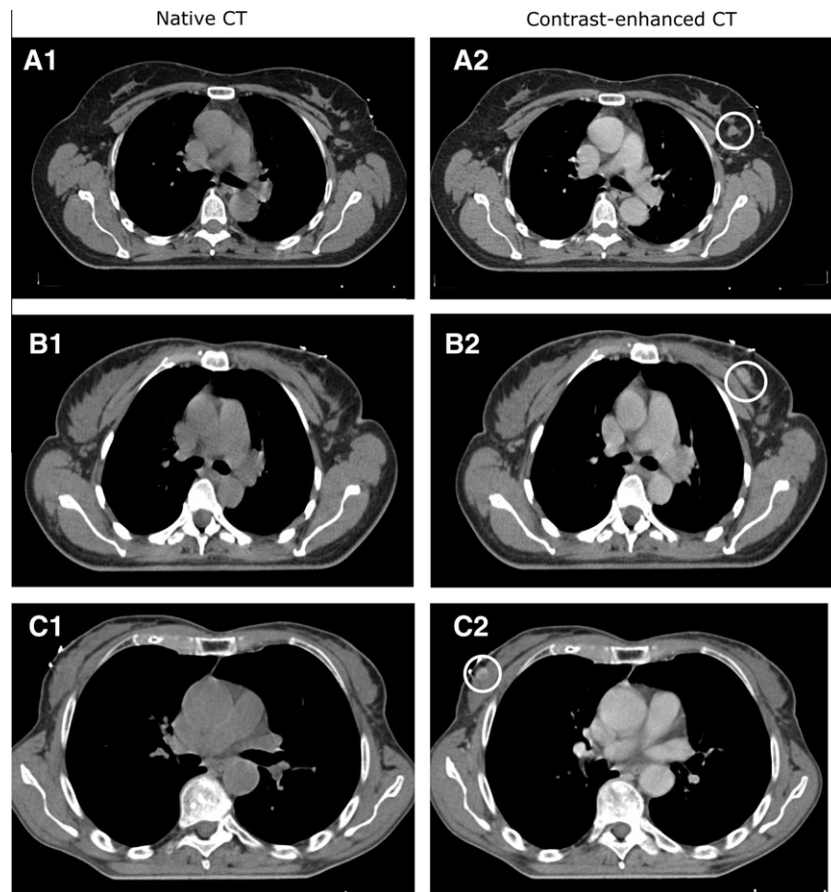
Example of a clearly visible (A), doubtfully visible (B) or invisible tumor (C) on the native CT (A1–C1), with the corresponding CE-CT (A2–C2).
